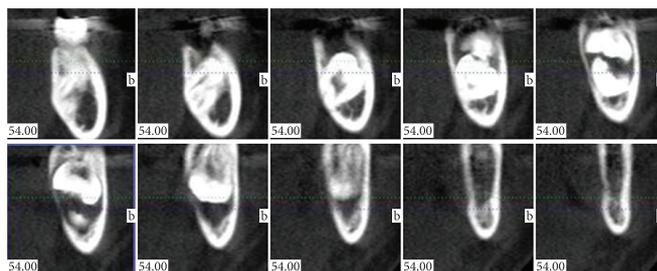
Computed Tomography spotlighting the resorption of lingual bone.
